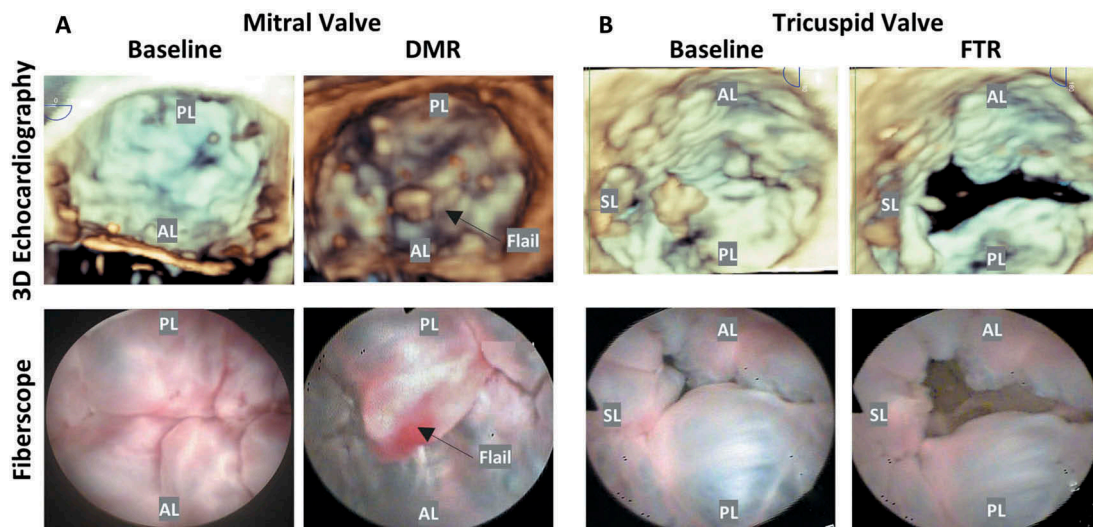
Ex-vivo pathological models: Representative 3D echocardiographic (upper row) and fiberoptic (lower row) images in the atrial view of baseline and pathological models of mitral (A) and tricuspid (B) valve. PL, posterior leaflet; AL, anterior leaflet; SL, septal leaflet.
